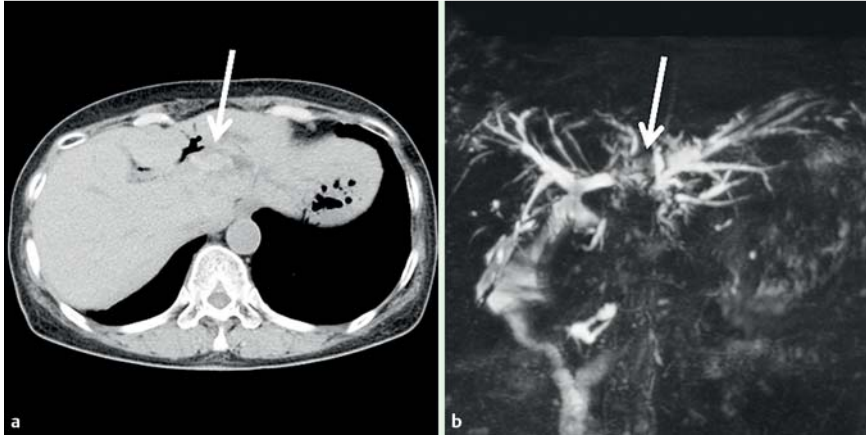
Images of a hepatolith (white arrow), 20 mm in diameter, in the left intrahepatic bile duct on: a a computed tomography (CT) scan; b magnetic resonance cholangiopancreatography (MRCP).
